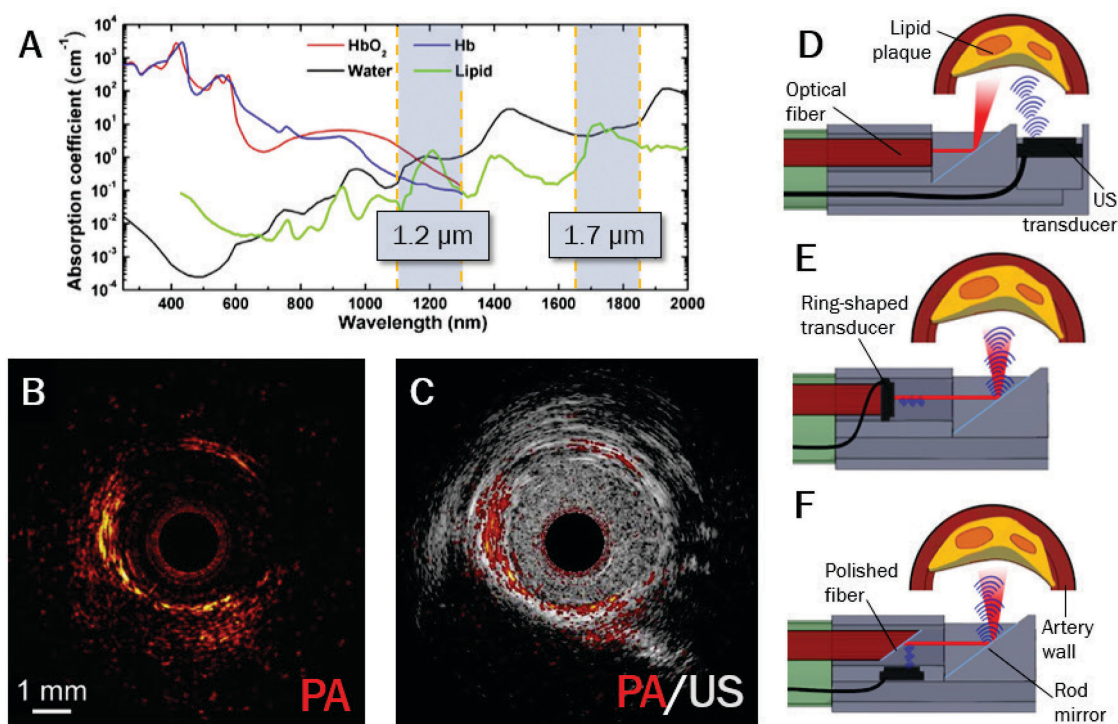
IVPA imaging theory, example, and catheter probe designs. A) Optical spectra showing absorption coefficient of lipid (green line) exceeds that of water (black line) at optical windows around 1.2 μm and 1.7 μm , thus making these wavelengths optimal for IVPA imaging. B, C) *In vivo* imaging of the abdominal aorta of an atherosclerotic rabbit reveals plaque lipid in the PA channel shown in B and localized within the artery wall when merged with the US channel shown in C. D) Front-to-back catheter design introduced by the Emelianov group and advanced by many others, in which there is an offset between the optical path reflection and transducer side-firing. This design has been miniaturized by the van Soest group to 1.3 mm in diameter with a sheath. E) Coaxial catheter design introduced by the Cheng group in which a ring-shaped transducer around the optical fiber allows for uniform optical and acoustic path overlap. However, further miniaturization of ring-shaped transducers is not currently feasible, limiting the probe diameter to a clinically-incompatible diameter of 2.9 mm. F) Collinear catheter design introduced by the Cheng group in which a series of reflections also allows for uniform optical and acoustic paths overlap in a smaller diameter probe (1.6 mm with sheath, data not yet published). This design has also been modified to reduce the number of ultrasound reflection surfaces and minimize signal loss by positioning of the transducer at a 10° angle for direct interrogation of tissue (quasi-collinear design, data not yet published). Panels A, B and C, D, E, and F adapted from Hui et al. (*Photoacoustics*, 2016), Wang et al. (*Ultrasound Med Biol*, 2012), Karpouk et al. (*Rev Sci Instrum*, 2010), Wang et al. (*Sci Rep*, 2014), and Cao et al., (*Sci Rep*, 2016), respectively.
